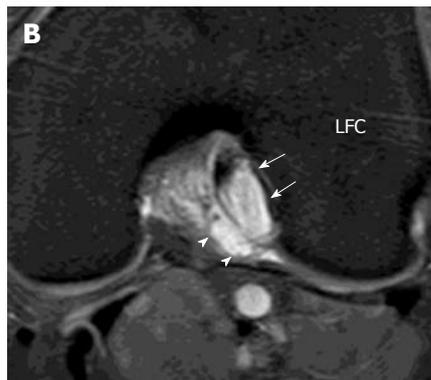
Celery stalk sign (mucoid degeneration). Sagittal intermediate-weighted magnetic resonance (MR) image. A: Enlargement of anterior cruciate ligament (ACL) (white arrows) with increased signal intensity compatible with mucoid degeneration. Low-signal-intensity fibres running parallel to the long axis of high signal ACL i.e. celery stalk sign; B: Axial intermediate-weighted fat suppression MR image shows cystic change within the ACL (white arrows) predominantly in the PL bundle. LFC: Lateral femoral condyle.
